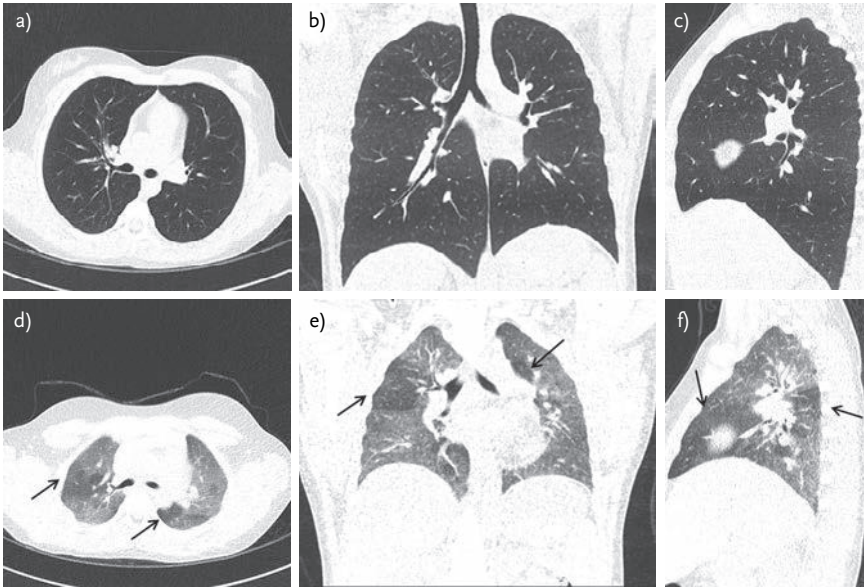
a–c) A spirometer-controlled inspiratory chest CT reconstructed in the axial (a), coronal (b) and sagittal (c) planes. Note that the lung is positioned between the heart and the sternum and that the lung is protruding between the ribs. d–f) A spirometer-controlled expiratory chest CT reconstructed in the axial (d), coronal (e) and sagittal (f) plane. Arrows indicate lucent regions of the lung caused by hypoperfusion and/or trapped air. The lucent areas are adjacent to normal dense regions, representing a mosaic pattern.
